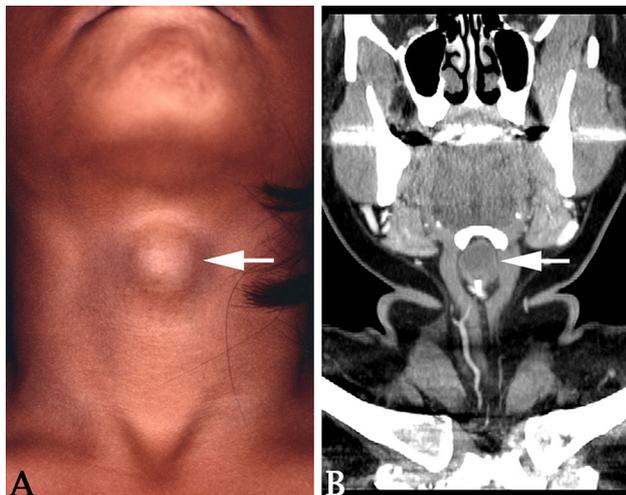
Clinical manifestations of thyroglossal duct remnant cysts. a An infrahyoid midline neck mass (arrow), which was soft and mobile with tongue protrusion. b A computed tomography scan showing a midline cystic mass (arrow) immediately below the hyoid bone
